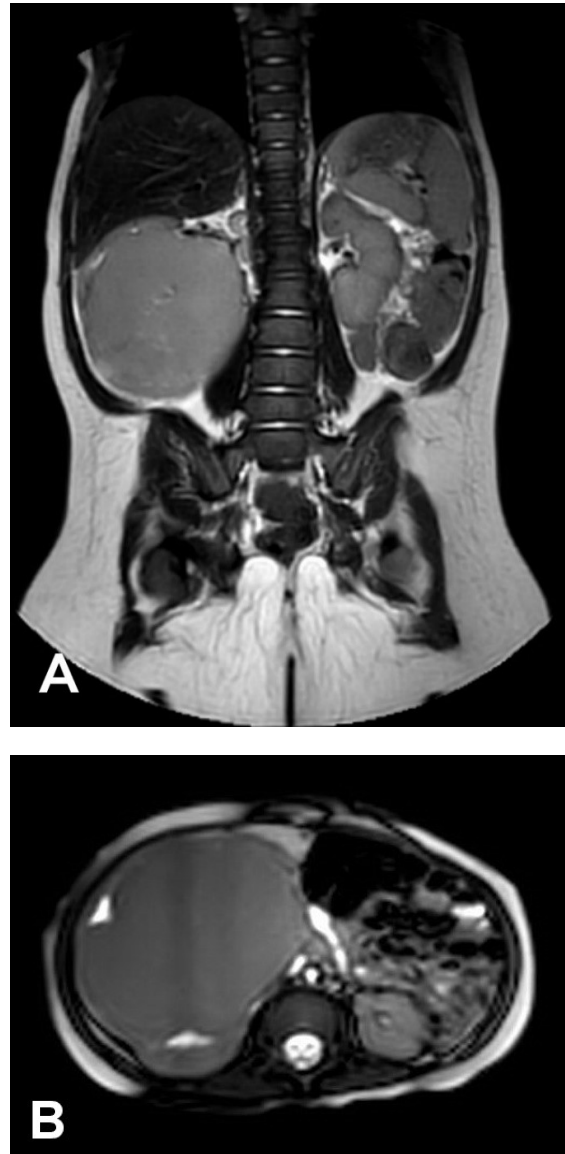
Right Wilms tumor at pre-op MRI after 4 cycles of chemotherapy.
